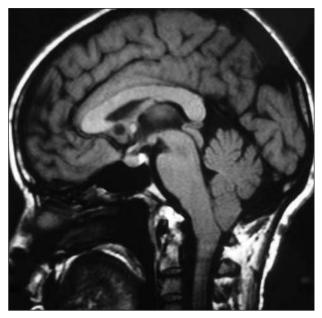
Sagittal T₁-weigthed brain MRI scan, showing Chiari type 1 malformation. Ectopia of the cerebellar amygdalae descending to top level of C2 is seen.
